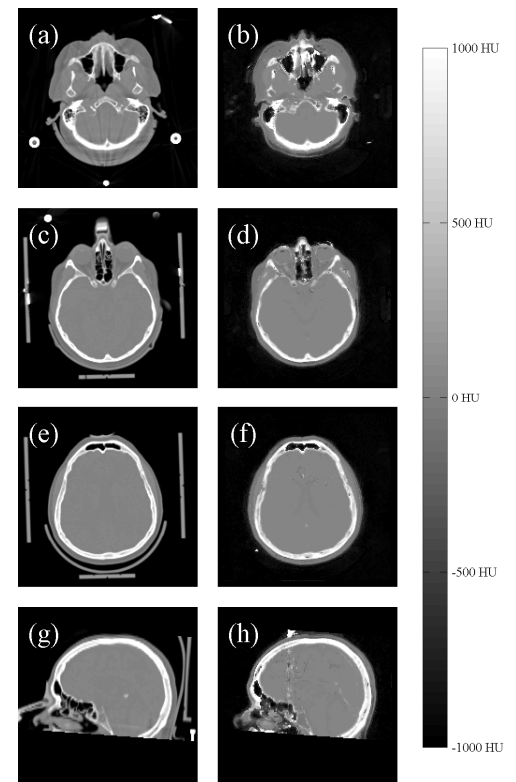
A real CT (a, c, e, g) and a substitute CT derived from MR images of the same patient (b, d, f, h). The fixation used during CT imaging is also seen in the real CT images.
